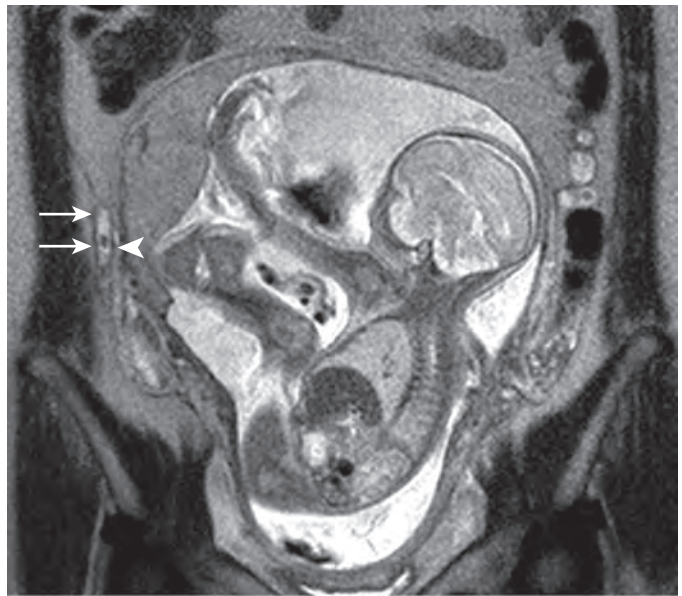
Appendicitis: MR features. An inflamed appendix (arrows and arrowhead) characterized by mural thickening, intraluminal fluid, and periappendiceal inflammation is depicted along the lateral aspect of the placenta on this T2-weighted coronal image obtained in a pregnant woman in the third trimester.
